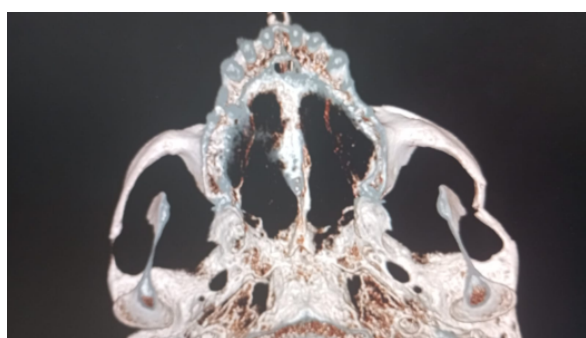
Computed tomography image demonstrating a left zygomatic arch fracture.
